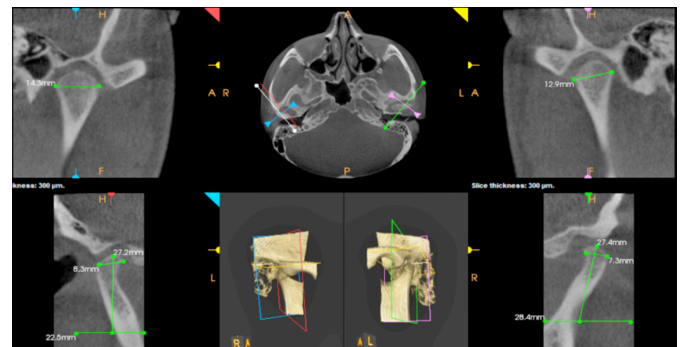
TMJ custom slicing using CBCT to obtain anteroposterior and coronal three-dimensional views of mandibular condyles.
